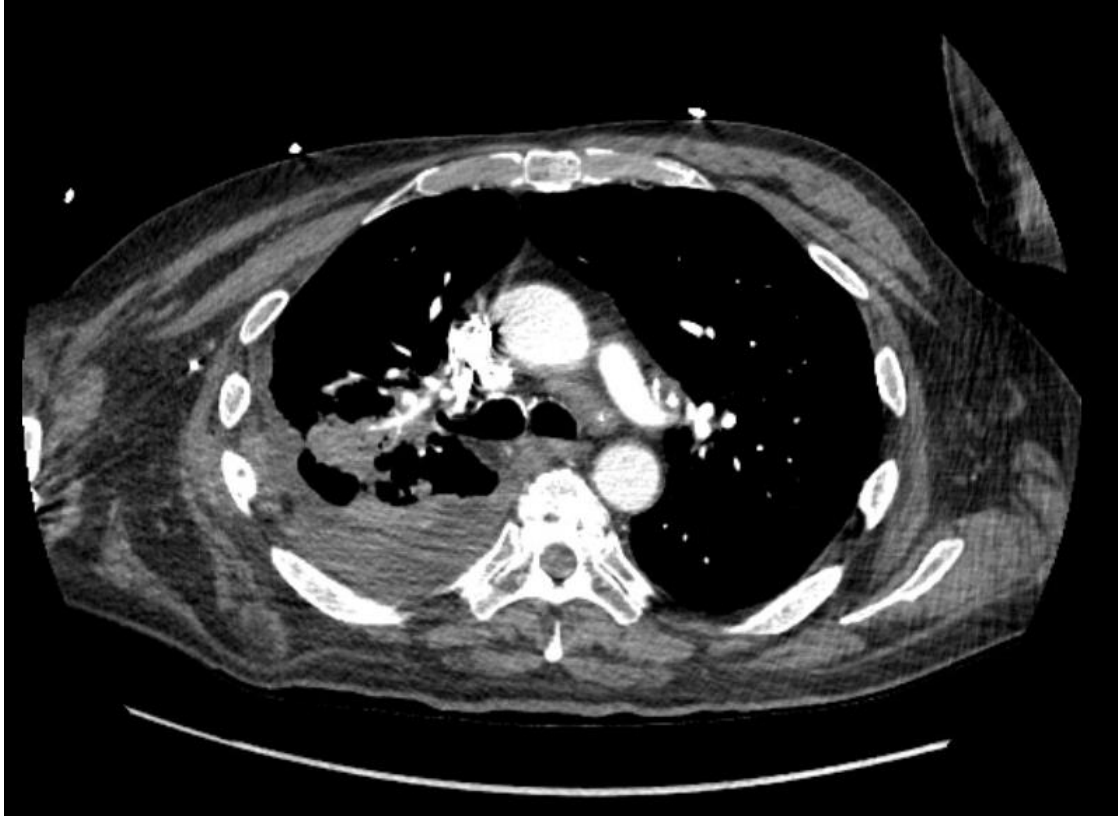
CT chest with contrast showing moderate right sided loculated pleural effusion as evidenced by its convex shape and septations.
